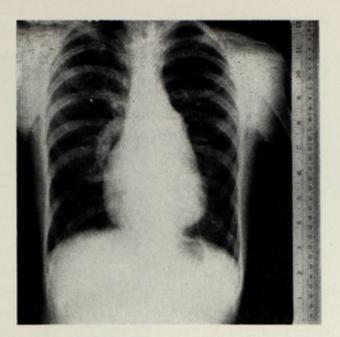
X-ray film in case of Marfan syndrome in which atrial septal defect was incorrectly thought to be present.
